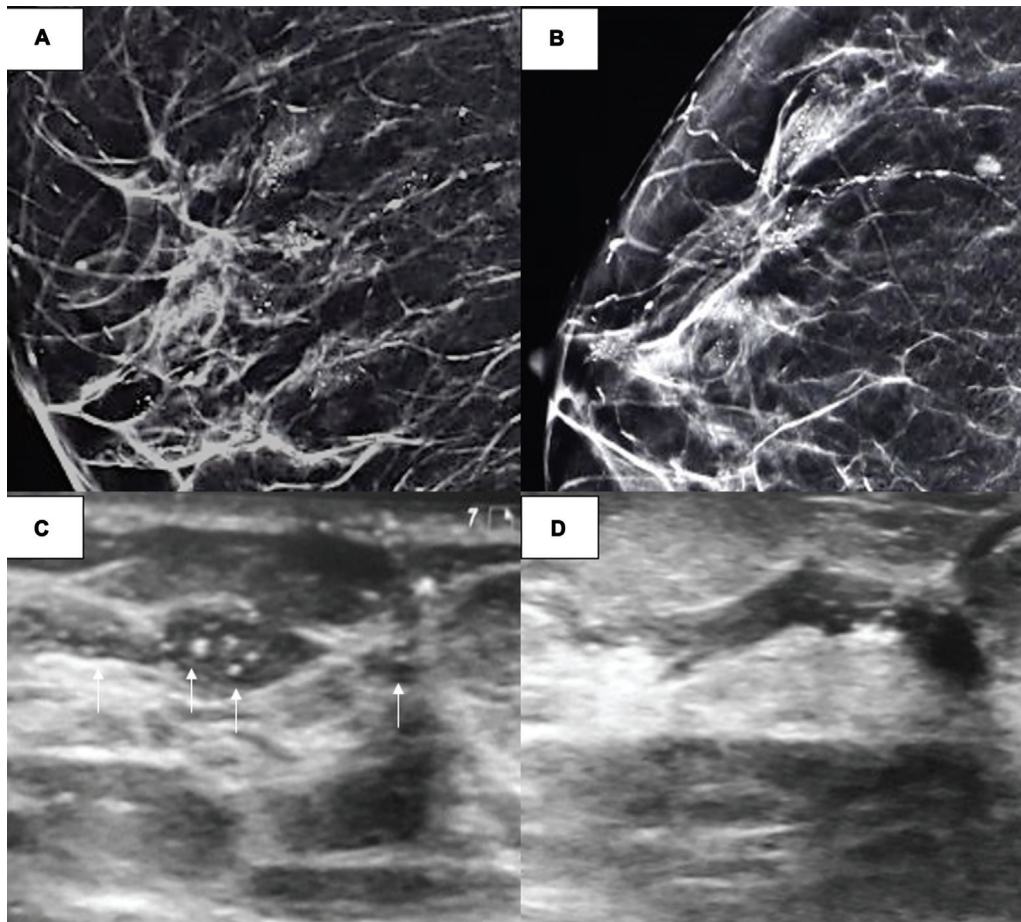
High-grade ductal carcinoma in situ (DCIS) as nonmass finding. Screening mammogram of BRCA 1 positive female with history of ovarian cancer in 2019 (A & B) revealed coarse heterogeneous calcifications in upper outer and central quadrants. Corroborative ultrasound (C & D) showed linear/tubular hypoechoic structures representing dilated ducts in the corresponding region with hyperechoic specks of calcification within (arrows in C). Stereotactic biopsy diagnosed it as high-grade DCIS.
